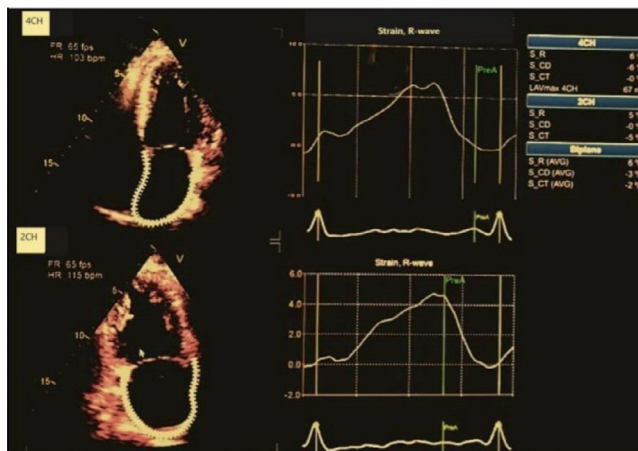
Strain curves from left atrial speckle-tracking, in apical four-chamber and two-chamber.
